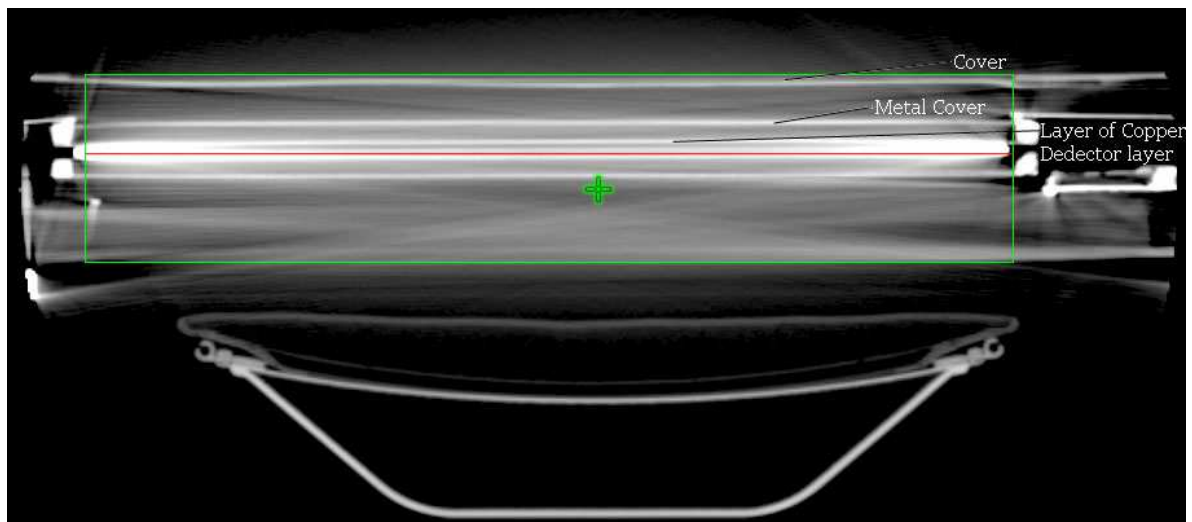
CT-slice in transversal direction of the Varian aS1000 EPID
